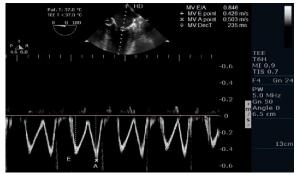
Transmitral flow velocity: E, A, E/A ratio, and the deceleration time by PW Doppler.
